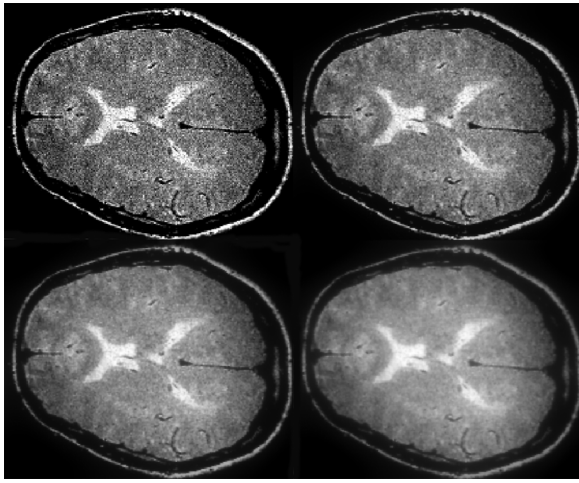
MR image of the Brain before (top-left) and the results of applying the fractional anisotropic diffusion algorithm given in Appendix III for a Prewitt edge detector after 5 (top-right), 10 (bottom-left) and 15 (bottom-right) iterations with $\Delta = 0.05$ and $\alpha = 1.98$.
